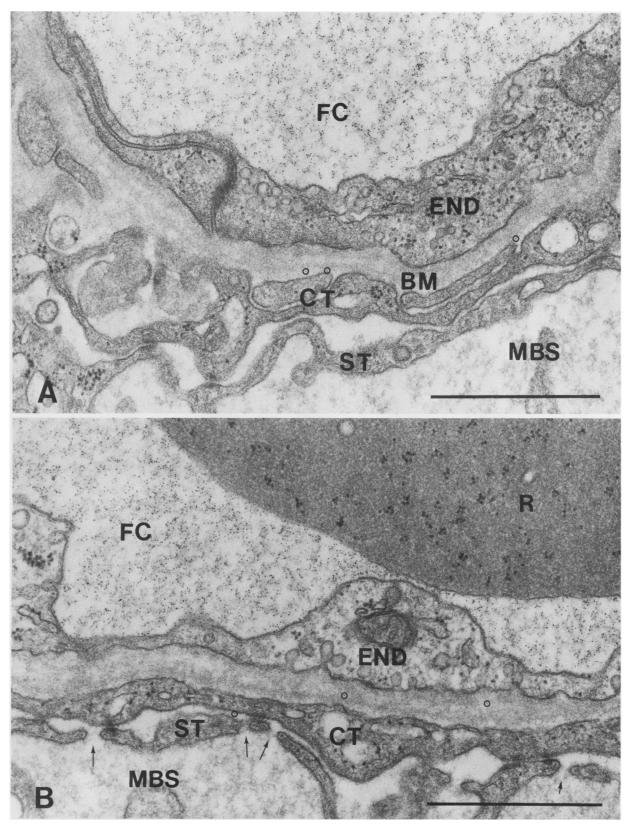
Ferritin injections into the fetal circulation. Ferritin particles in the basement membrane (BM) have been circled. A shows an endothelial cell junction, common in epithelial plates. B shows a great abundance of ferritin-filled vesicles in the endothelium (END), some seemingly arranged in chains, and a fetal reticulocyte (R). Both figures show the invaginations in the cytotrophoblast (CT), and B shows the pores (arrows) in the syncytio-trophoblast (ST). Basement membrane matrix material may partially fill the endothelial junctions. Bars are $1 \mu m$.
